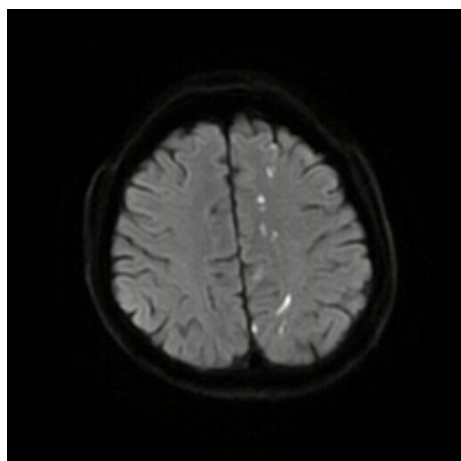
DWI examination in the second patient. DWI, diffusion weight imaging.
